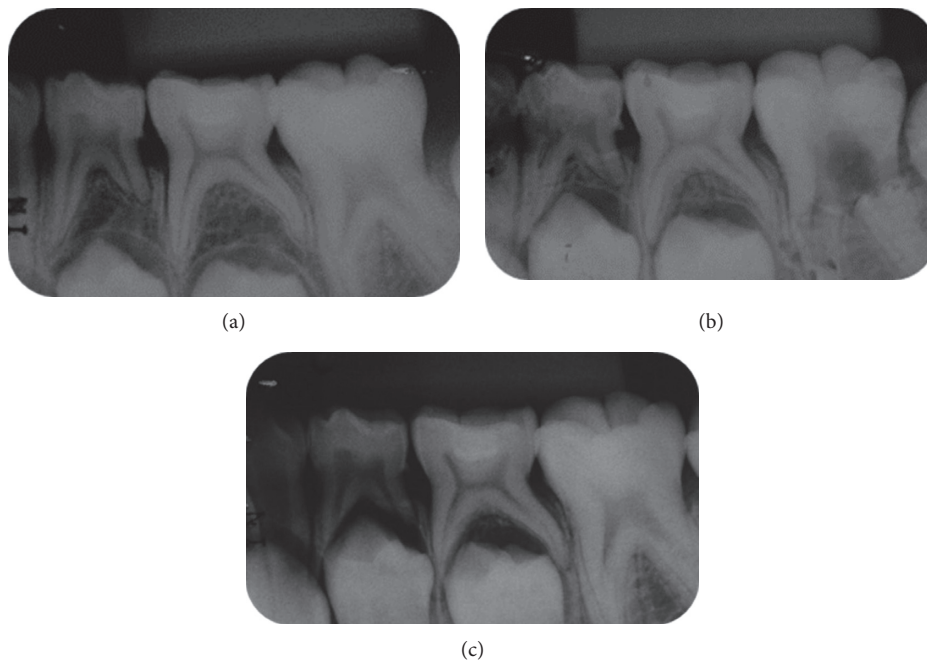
Radiographic following-up: (a) 6 months, (b) 12 months, and (c) 18 months.
